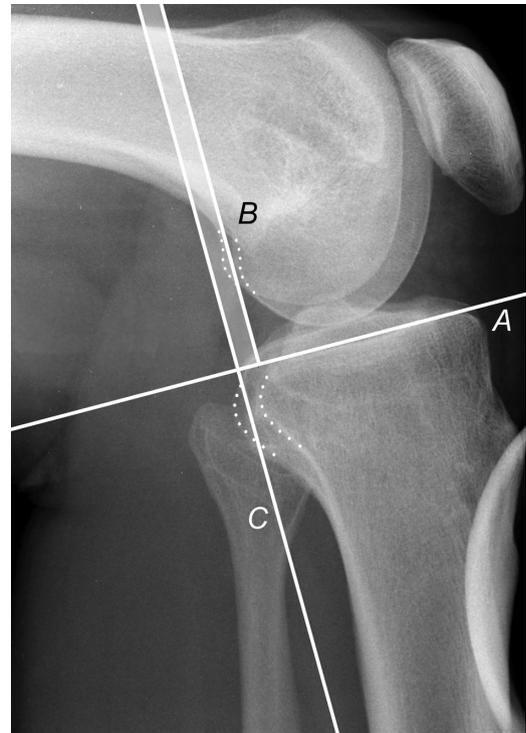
Lateral stress radiograph depicting the measurement of the tibial slope. The tibial slope (asterisk) is defined as the angle between A and B with respect to C, a line perpendicular to the longitudinal axis of the tibia.<sup>15</sup>
